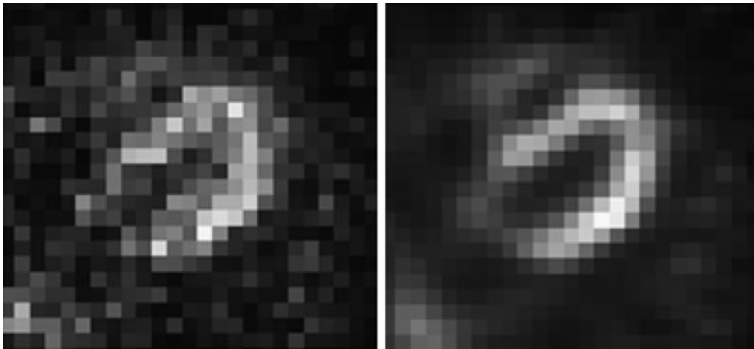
SPECT image of the left ventricle. The two images are not smoothed in order to reveal their true spatial resolution. The *left image* was reconstructed without, the *image on the right* with attenuation correction using the method of Celler et al. (2005) (with kind permission of Anna Celler, Department of Radiology, University of British Columbia, Vancouver)
